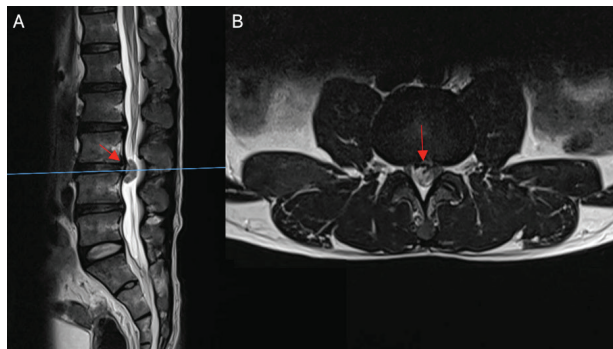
A Herniated Disc Located L3/4 on Lumbar MRI (red arrow). A heterogenous hypointense mass measuring 6x7x18mm is observed on T2-weighted image in sagittal section (A), and the central hernia is slightly displaced towards the right side in axial section (B), leading to spinal stenosis that compresses the cauda equina nerve root
